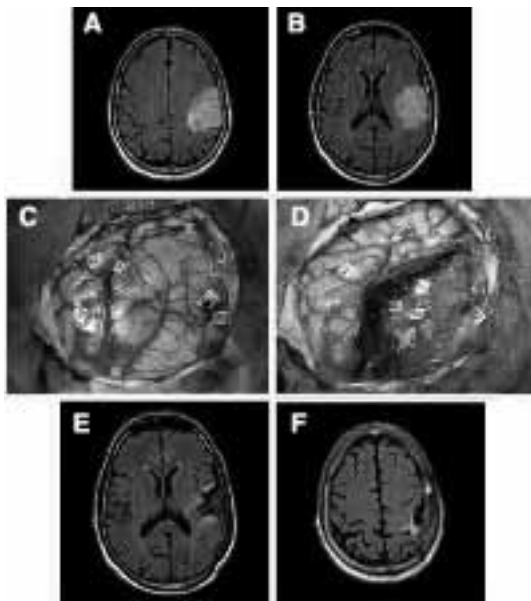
Preoperative axial FLAIR MR images (A and B) showing a low-grade glioma involving the left inferior parietal lobule as well as the retrocentral gyrus. Intraoperative photograph (C) of cortical mapping: letters show the tumor limits as indicated by ultrasonography. Moreover, electrostimulation identified the primary motor cortex of the face inducing facial movements (Number 46) as well as the region eliciting speech arrest (ventral premotor cortex, Number 8). Anomia was also generated by stimulation over the posterior third of the superior temporal gyrus (Wernicke Area, Number 47). Intraoperative photograph (D) of the surgical cavity, with no margin around the eloquent regions, showing the subpial dissection all along the central sulcus and the sylvian fissure (anteroinferior margin). Thus, we removed the retrocentral gyrus that did not respond to stimulation. In addition, the subcortical functional boundaries, pyramidal fibers of the face (projection fibers, Number 48), arcuate fasciculus generating phonemic paraphasias (Number 49), and the frontoparietal articulatory loop generating dysarthria (Number 50)—both constituting the long-distance association pathways or deep connectivity—represented the subcortical functional boundaries of the resection. Postoperative axial FLAIR MR images (E and F) showing removal of the retrocentral gyrus and inferior parietal lobule. The surgical cavity came in contact with the central sulcus without any margin (subpial dissection) as well as with the arcuate fascicle.
